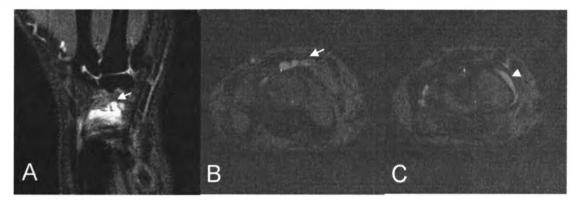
Case 1 left wrist MR images.
